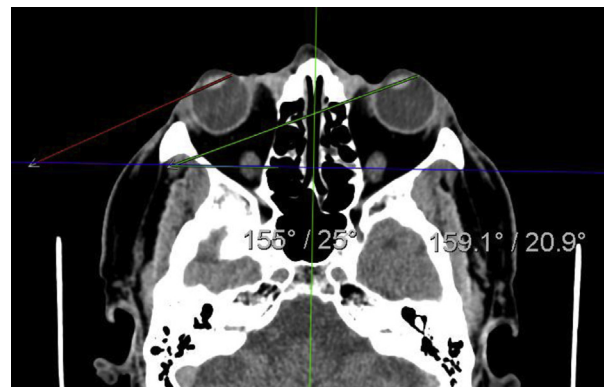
"DeyeCOM sign" on noncontrast computed tomography scan of the head in a stroke code patient presenting to the emergency department. The right eye was deviated 25° and the left 20.9°.
